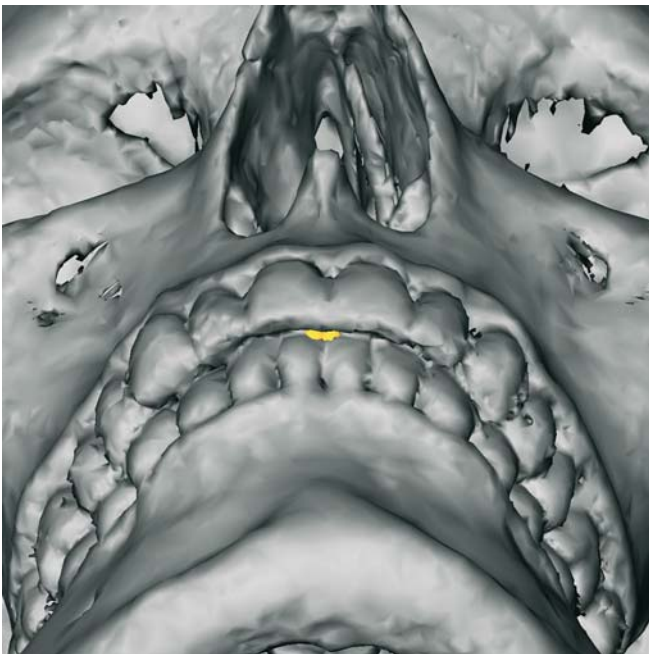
Lower Incisor_r and Lower Incisor_l landmarks. Submental view (3-D CT, patient K.C.)
